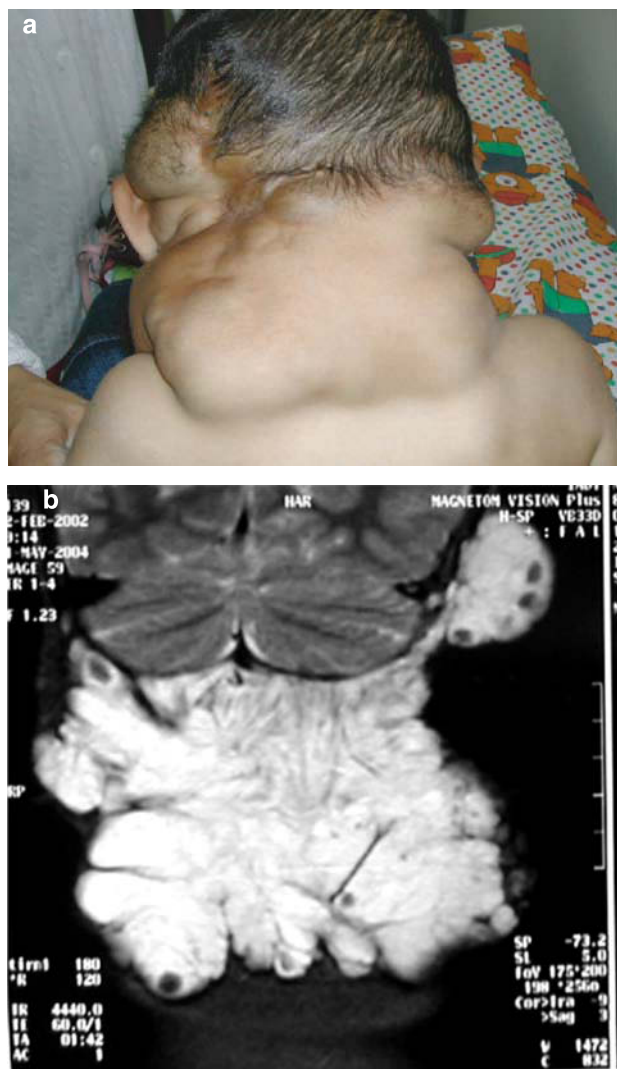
(a) A large, complex, disfiguring, cavernous lesion of the neck and upper shoulders compressing vital structures in a child with BRBNS; (b) coronal T2-weighted MR image shows marked increased signal intensity of the venous component of a large tumour in the posterior fossa.
